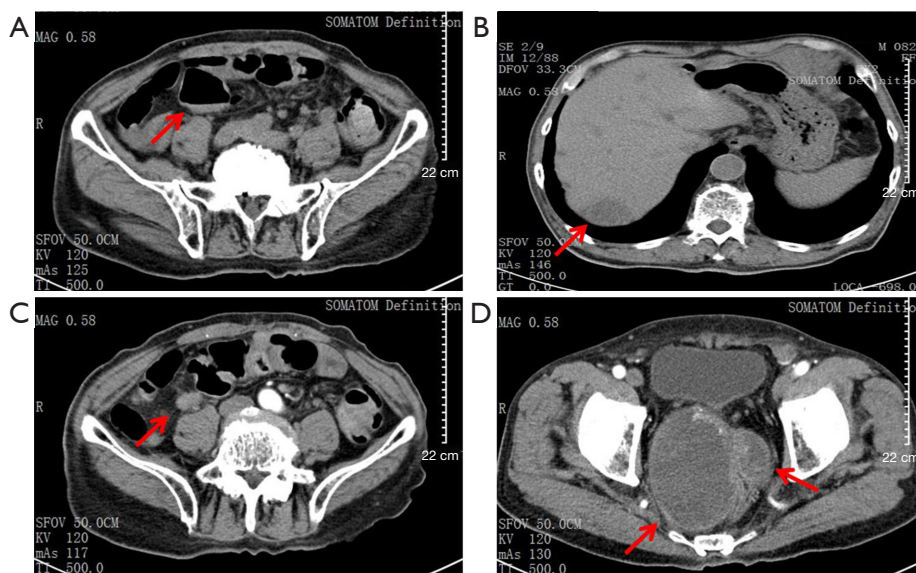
Abdomen CT images before fruquintinib treatment in December 2018. (A) Dilated intestinal canal with an air-liquid level, indicating intestinal obstruction (red arrow). (B) Multiple metastases in the liver (red arrow). (C) Mesenteric lymph node metastasis (red arrow). (D) Giant metastasis in the pelvic cavity (red arrows).
